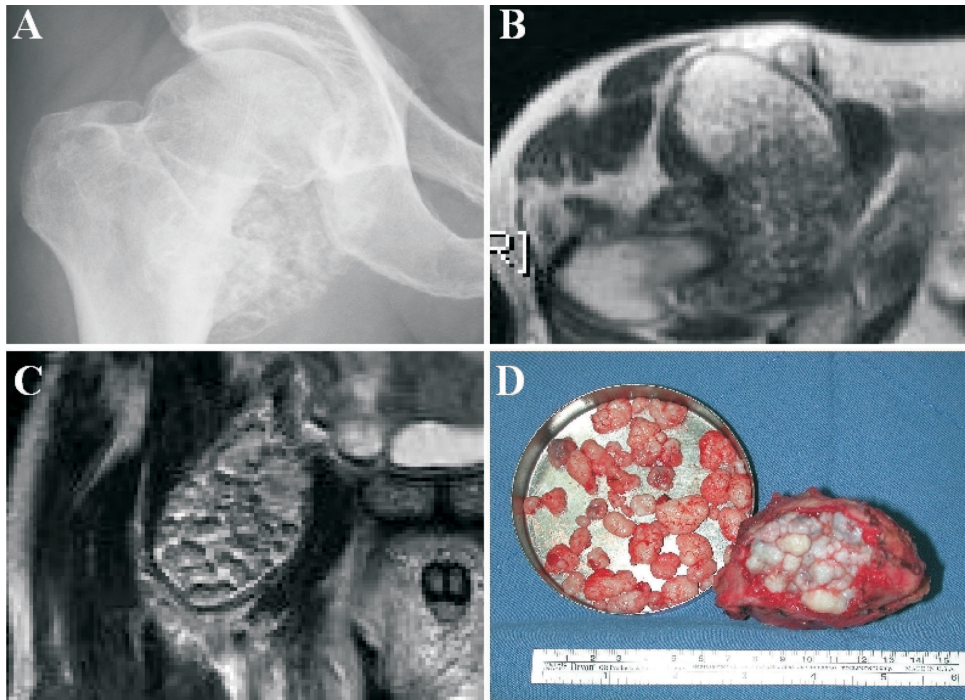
A 72-year-old man presented with synovial chondromatosis of the right hip. (A) Pelvic anteroposterior plain radiograph. (B) and (C) Magnetic Resonance Imaging (D) Gross pathology.
